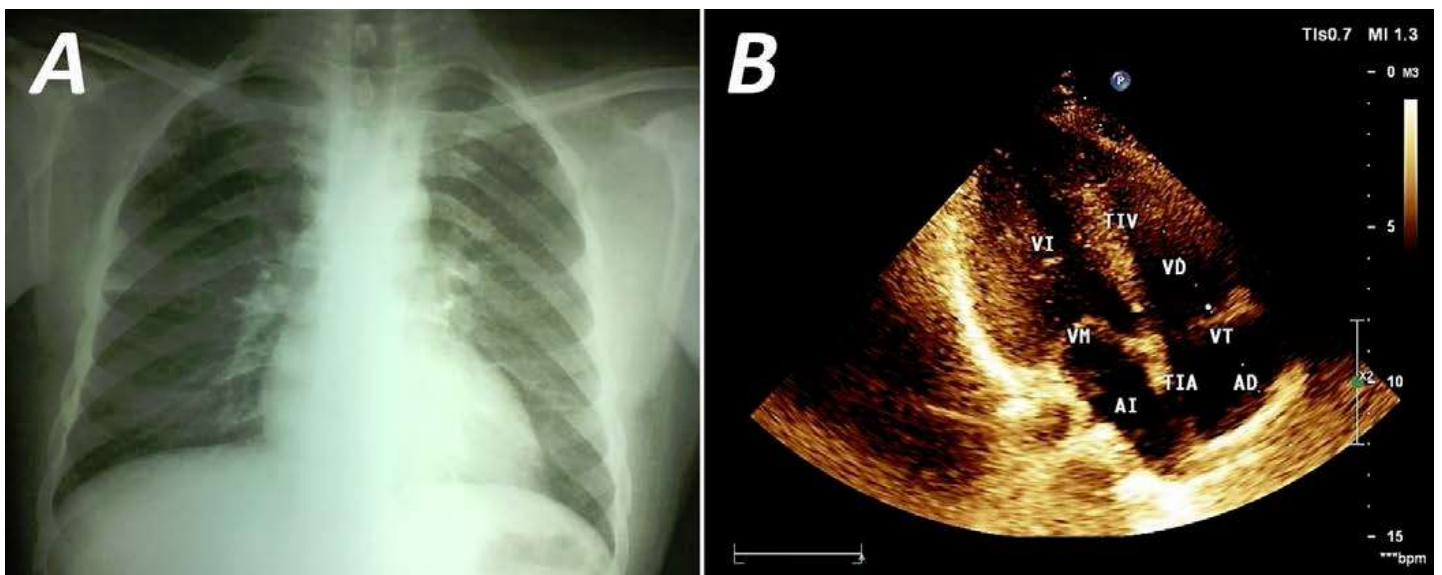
A. Posteroanterior chest radiography and B. Transthoracic echocardiogram showing improvement of the radio-graphic lesions and disappearance of intracardiac mass, after specific antibiotic treatment. Acronyms in Spanish: *AD*, right atrium; *AI*, left atrium; *TIA*, interatrial septum; *TIV*, interventricular septum; *VD*, right ventricle; *VI*, left ventricle; *VM*, mitral valve; *VT*, tricuspid valve. catheter for hemodialysis, which was used considering that after transplantation, the functionality of arteriovenous fistulas of the upper left member had been lost. The large vegetation is explained for being a patient with immunodeficiency due to the CKD, which favored the proliferation of germ that usually produces large vegetation, as fungi do it In all patients with terminal CKD, dependent on hemodialysis through central venous catheter, the appearance fever should be paid special attention, because intravascular catheters are risk factors for the entry of germs that can colonize the endocardial
